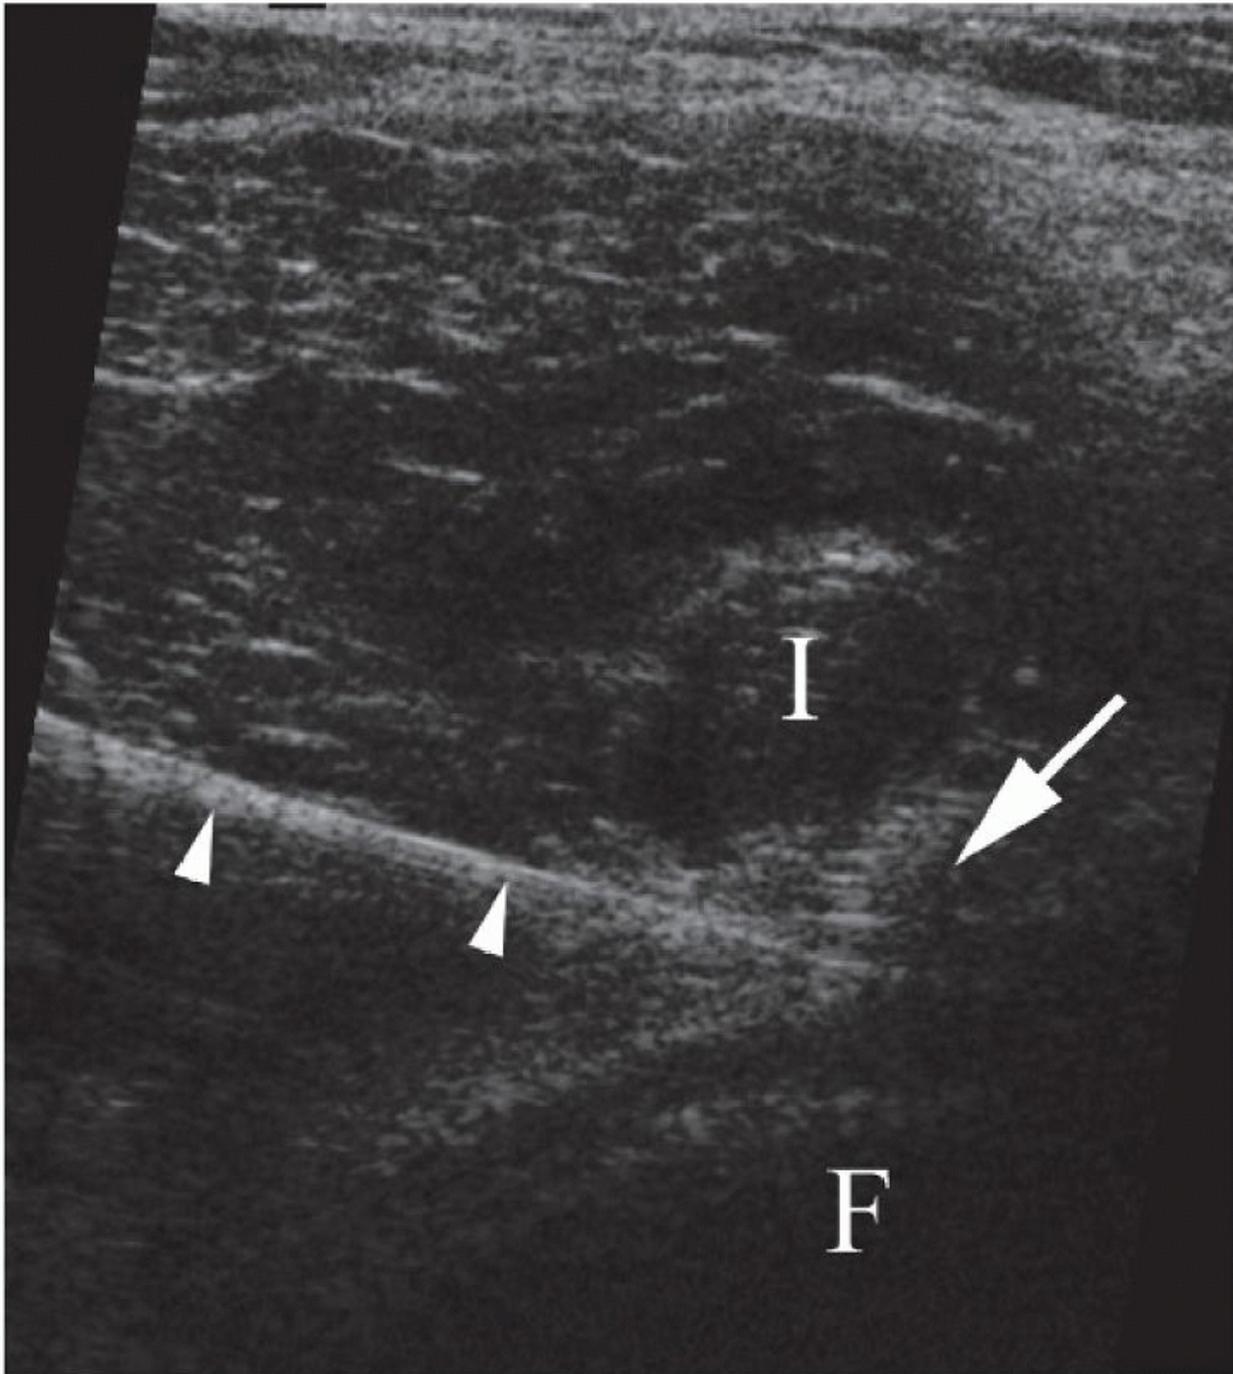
Iliopsoas tendon undergoing guided injection. Transverse sonogram demonstrates lateral approach injection of the iliopsoas muscle (I) and hyperechoic iliopsoas tendon (white arrow), which is being targeted with steroid and local anesthetic via the needle (white arrowheads) at the level of the femoral head (F).
